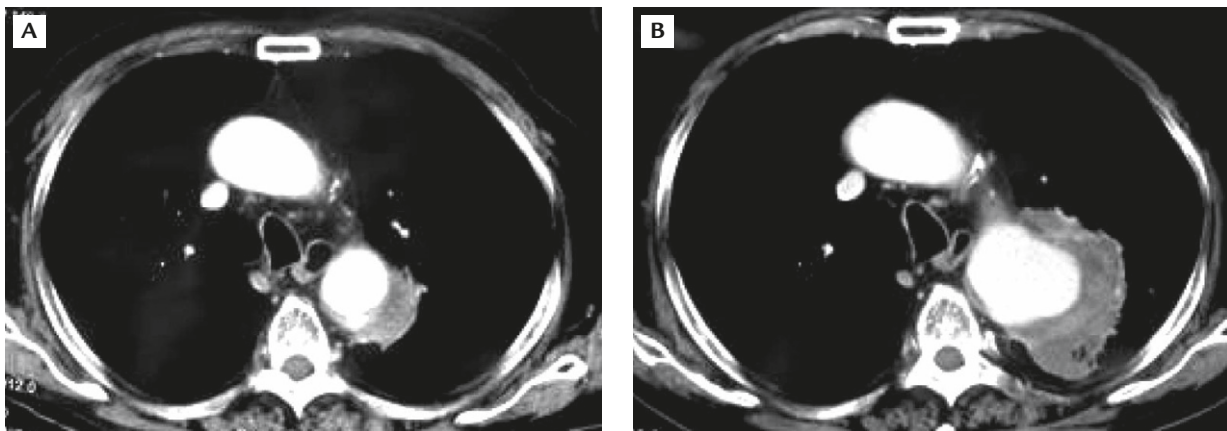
Computed tomography of the chest demonstrating: (A) dilated descending aorta with calcification and mural thrombi on day 3 of admission, and (B) enlarged aneurysm ruptured into the lung 1 week later.
